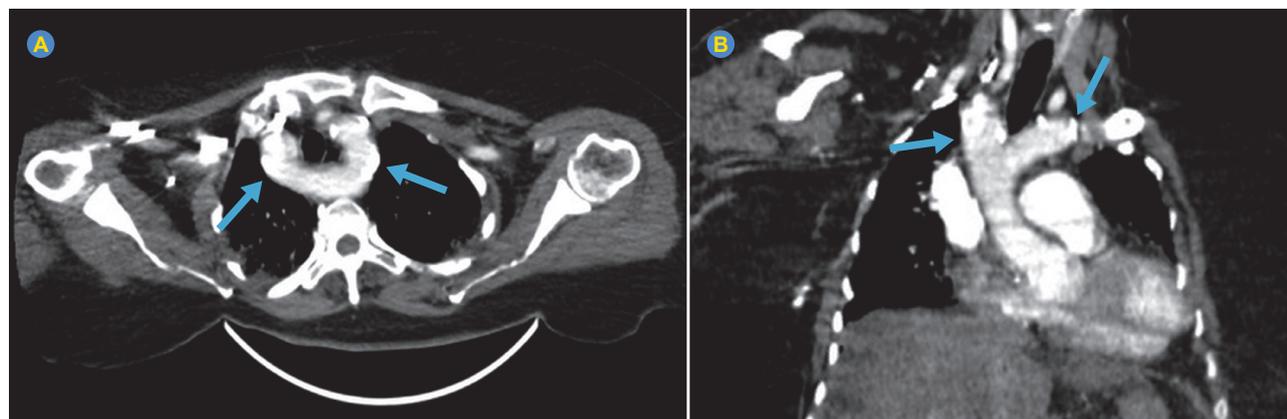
64-multislice CTA MIP images (7 mm) in axial (A) and coronal (B) demonstrating the double aortic arch (arrows) with a slight impression on the esophagus
